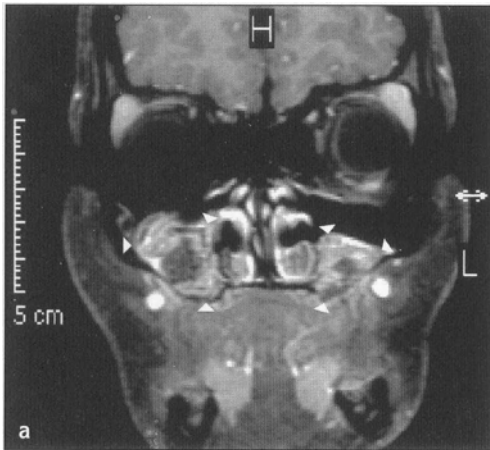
Nuclear magnetic resonance image with contrast agent of a patient 4 weeks (a) and 14 weeks (b) after receiving a sinus graft in both maxillary sinuses using autogenous bone from the iliac crest. (arrows) Receptient site. Note the difference in vascular supply of the graft: the central area (black), nonvascularized after week 4, is vascularized after week 14. (Courtesy of G. Mailath.)
